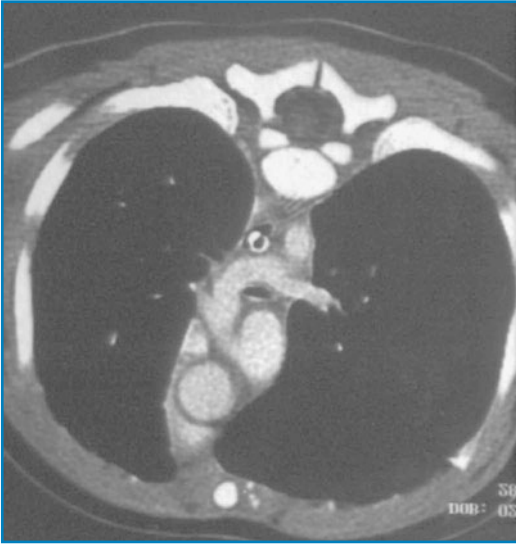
MRI of a pulmonary artery sling
